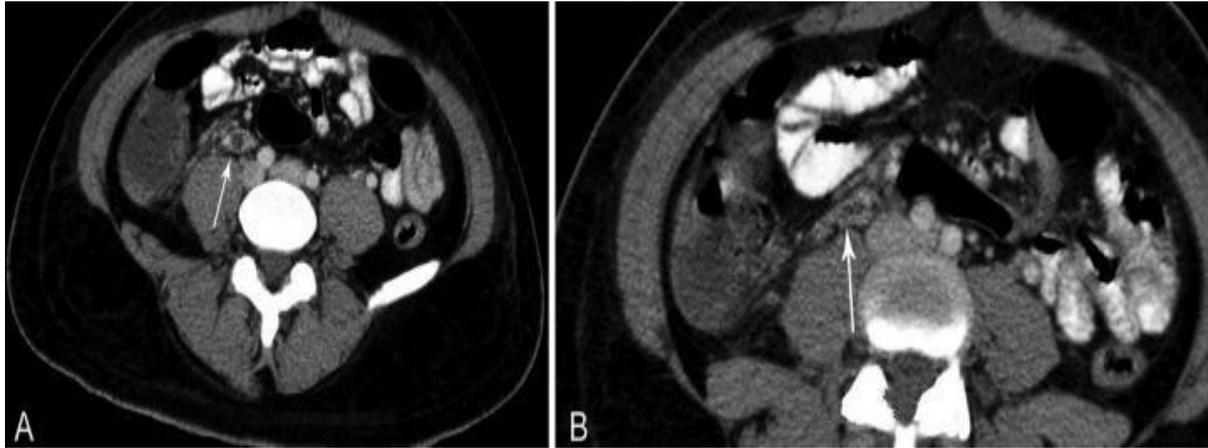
Axial contrast-enhanced CT of the abdomen and pelvis. The arrow indicates an enlarged right ovarian vein with a central low-attenuation thrombus and surrounding perivenous fat stranding
